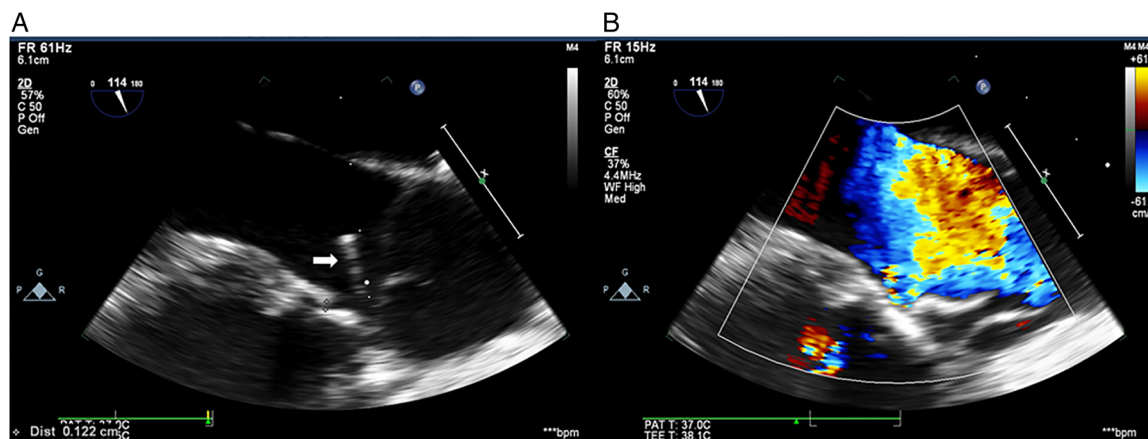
Intraoperative transoesophageal echocardiography showing right-to-left shunt across the valved patch (arrow) in a 9-year-old patient who underwent closure of a ventricular septal defect.
